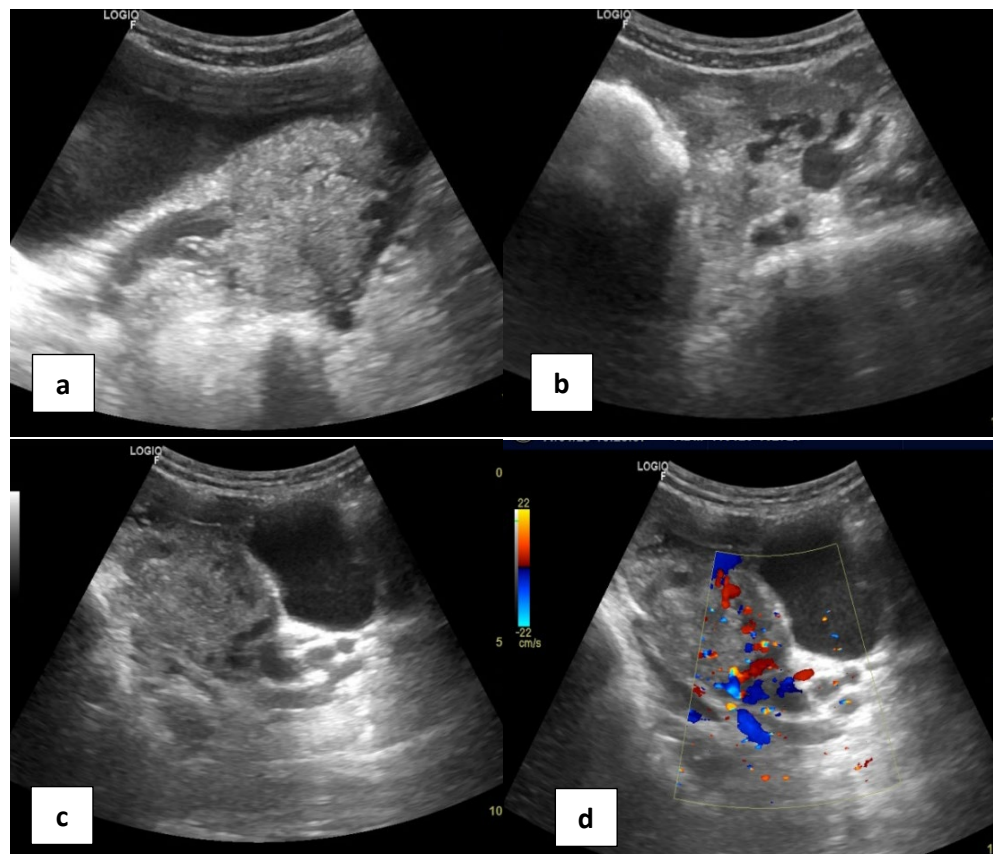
a,b) Axial sections shows dilated vascular channels in parametrium c) Sagittal images in left parametrium showing similar findings d) Doppler evaluation showing flow in these channels.
